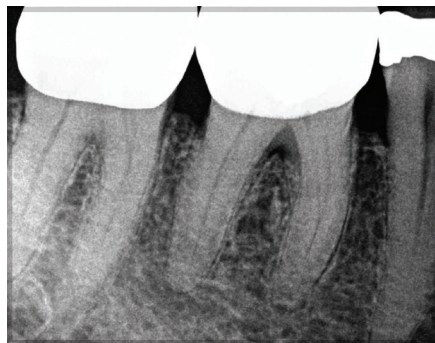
Periapical radiograph of the first molar, devoid of an intraosseous pathologic lesion.
